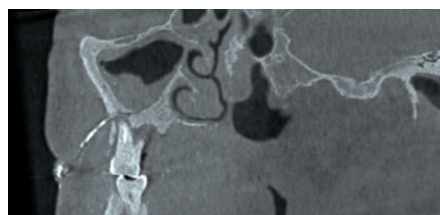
Accidental tracing with calcium hydroxide agent in CBCT image
